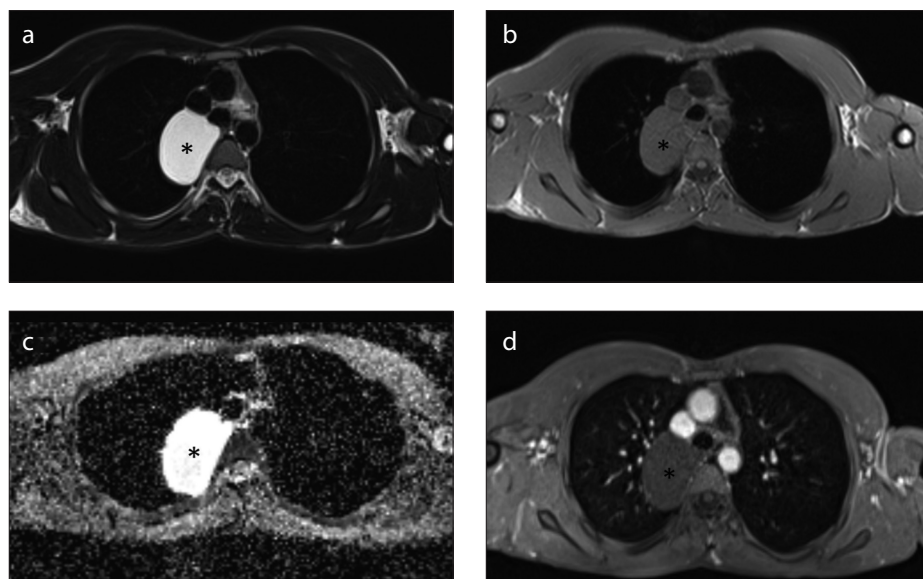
a-d. A 13-year-old female with a bronchogenic cyst in the right upper lobe. Axial T2-weighted fat-suppressed image (a) reveals a hyperintense bronchogenic cyst (black asterisk). Axial T1-weighted image (b) reveals a hypointense bronchogenic cyst (black asterisk). Axial diffusion-weighted (ADC map) image (c) exhibits no diffusion restriction (black asterisk). Axial postcontrast enhanced T1-weighted image (d) exhibits no contrast enhancement (black asterisk).
